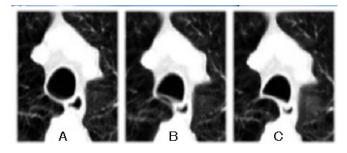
2D dynamic CT images of the trachea during resting expiration of a pulmonary emphysema.patient. Just before (A) and after (B) the beginning of expiration, and during expiration (C).
